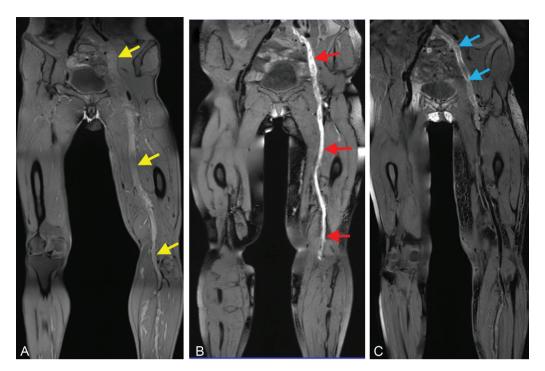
Thrombi in acute DVT patients present in (A) iso-, (B) hyper-, and (C) mixed iso-/hyper-intense signals on noncontrast T1-weighted black-blood MR images. *Yellow arrows* denote the iso-intense thrombi with comparable signal intensity to the adjacent muscle. *Red arrows* denote the hyper-intense thrombi with higher signal intensity than the adjacent muscle. *Blue arrows* denote the mixed iso-/hyper-intense thrombi compared to the adjacent muscle. DVT, deep vein thrombosis; MR, magnetic resonance.
